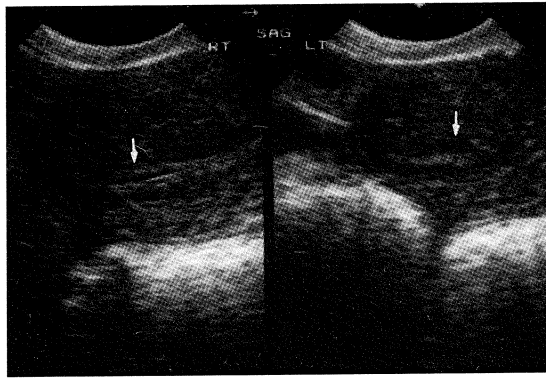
Transvaginal ultrasound. The endometrium can be traced from the uterine cavity to the most distal portion on both sides (white arrows). No lesion could be detected.
